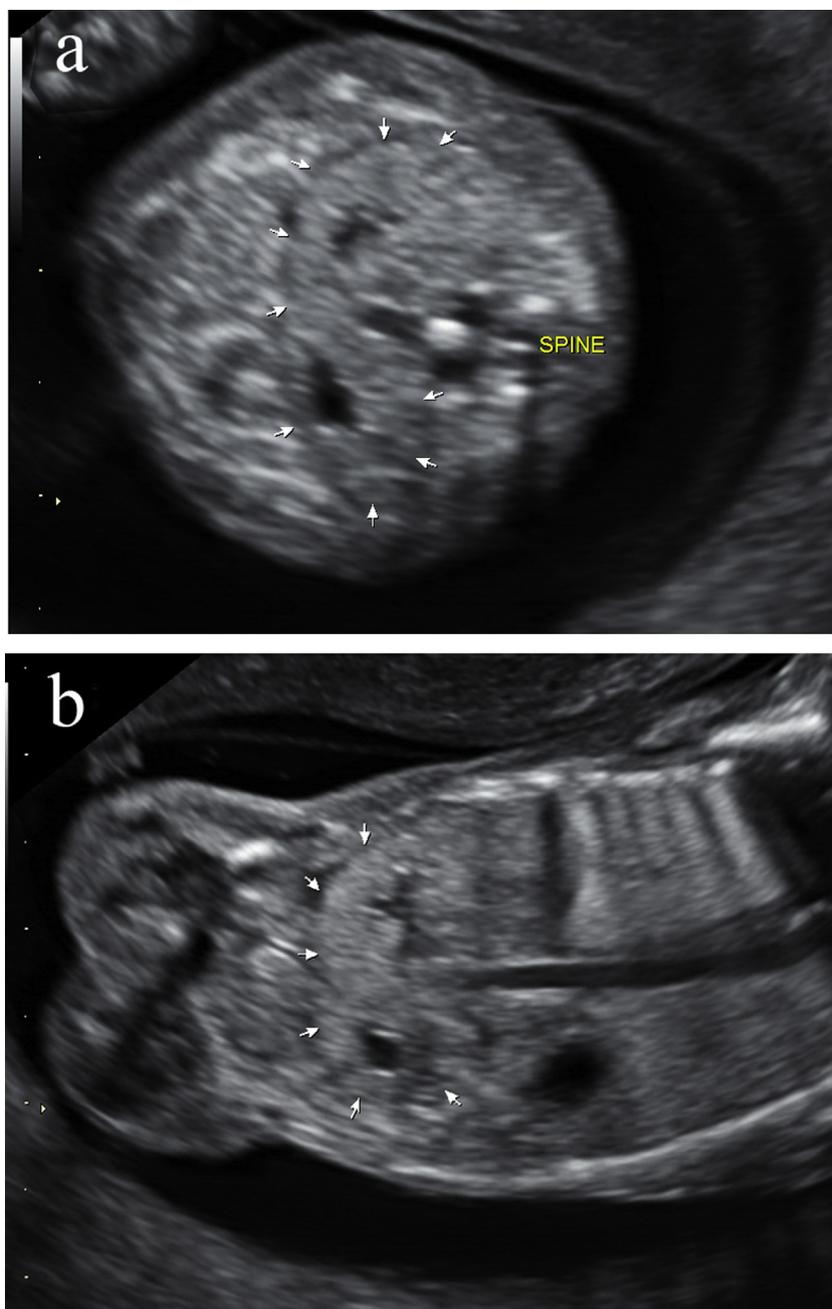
Sonographic demonstration of horseshoe kidney (marked by arrows), in (a) axial and (b) coronal views. On the courtesy of Dr. Israel Shapiro, Ultrasound Unit, Department of Obstetrics and Gynecology, Bnai-Zion Medical Center, Haifa, Israel.
